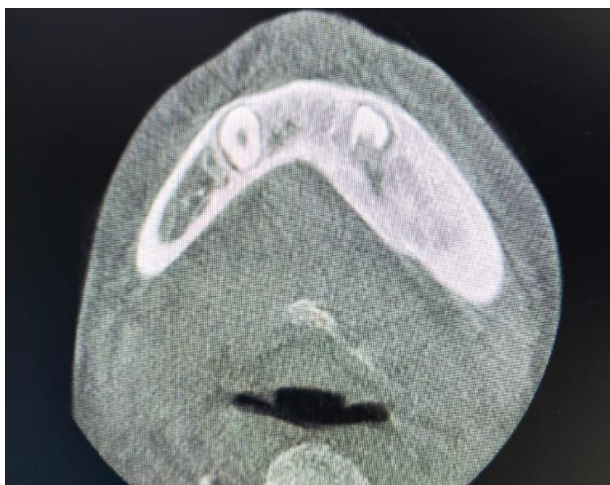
Axial view of CBCT showing ground glass appearance wrt left posterior lower region of mandible.
